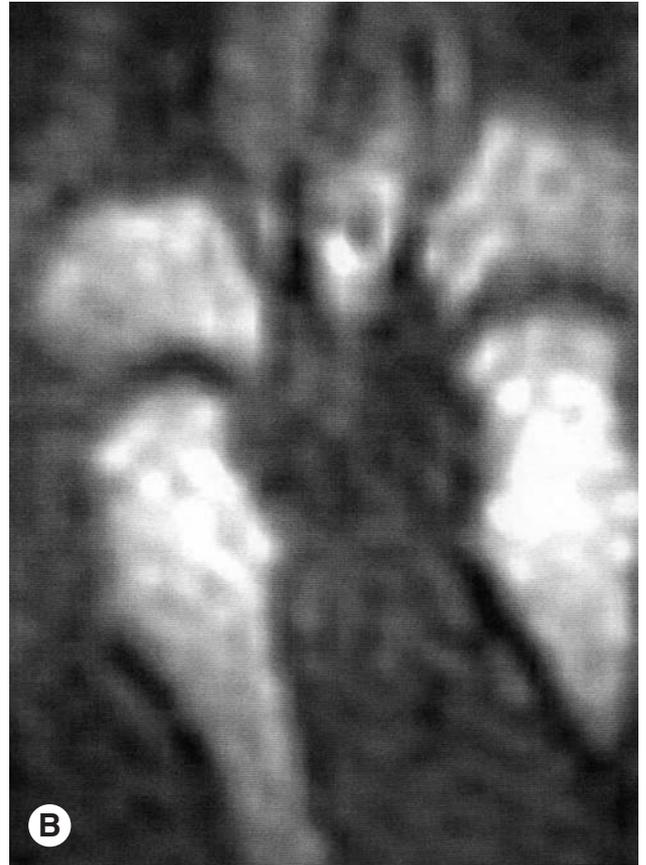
(Opposite page). New erosion detected by radiograph and MRI. A. PA radiograph obtained on March 27, 2003, showed no erosions of the left second and third MCP. B. The T1-weighted MRI obtained on the same date also showed no erosions. C. The PA radiograph obtained on September 8, 2003, showed a new marginal erosion involving the radial aspect of the second proximal phalanx (arrow). Other new erosions were also present. D. The T1-weighted MRI also shows the new erosion (arrow). Radial-side second MCP erosions are also present, but incompletely seen on this single tomographic slice.
